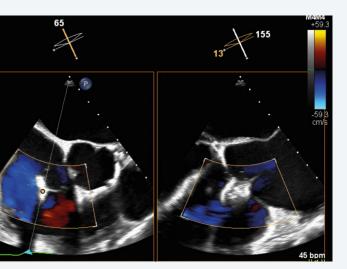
Transoesophageal echocardiography showing
